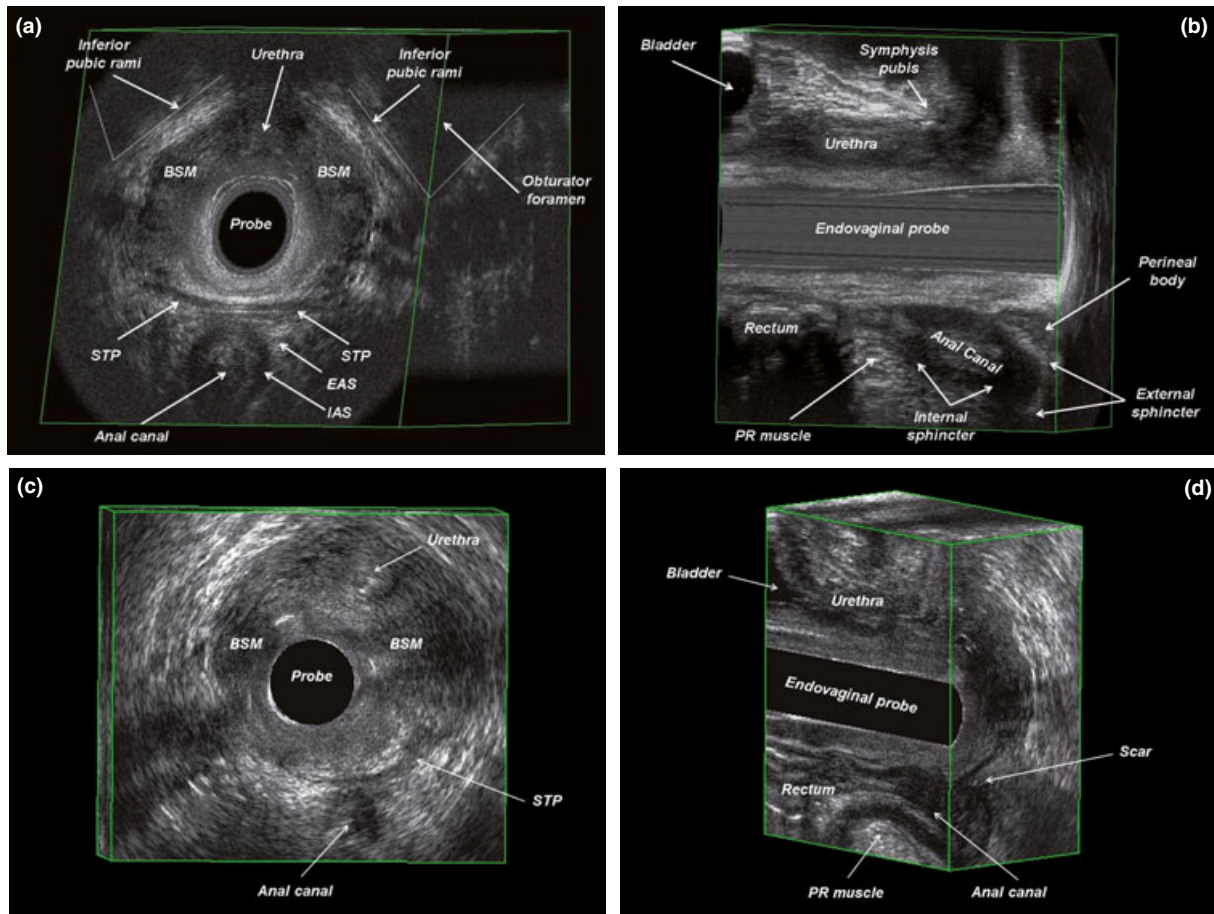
Endovaginal ultrasonography. (a) Axial image of the pelvic floor at level IV in a normal nulliparous woman. The superficial transverse perineii (STP) muscles are visualized as two hypoechoic bands lying transversally between the vagina and the anal canal. (b) Midsagittal image of the pelvic floor in a normal nulliparous woman. The perineal body appears as an oval hypoechoic structure. (c) Axial image of the pelvic floor at level IV in a patient with third-degree rectocele. The STP is visualized only on the left lateral side and is damaged on the contralateral side. (d) Mid-sagittal image of the pelvic floor in a patient with third-degree rectocele. The oval hypoechoic structure of the perineal body cannot be identified and is replaced by a mixed echogenicity area of scar. BSM, bulbospongiosus muscle; EAS, external anal sphincter; IAS, internal anal sphincter.
